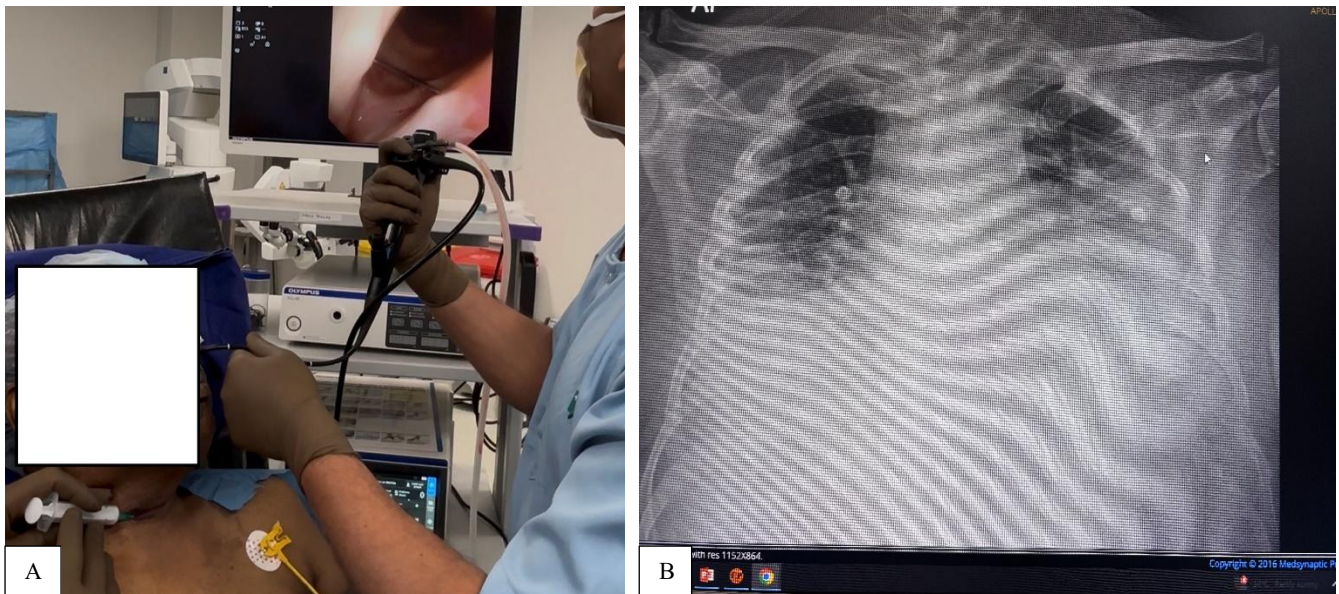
(A) Patient is awake and procedure being done and (B) X-ray showing extensive involvement due to metastases.
